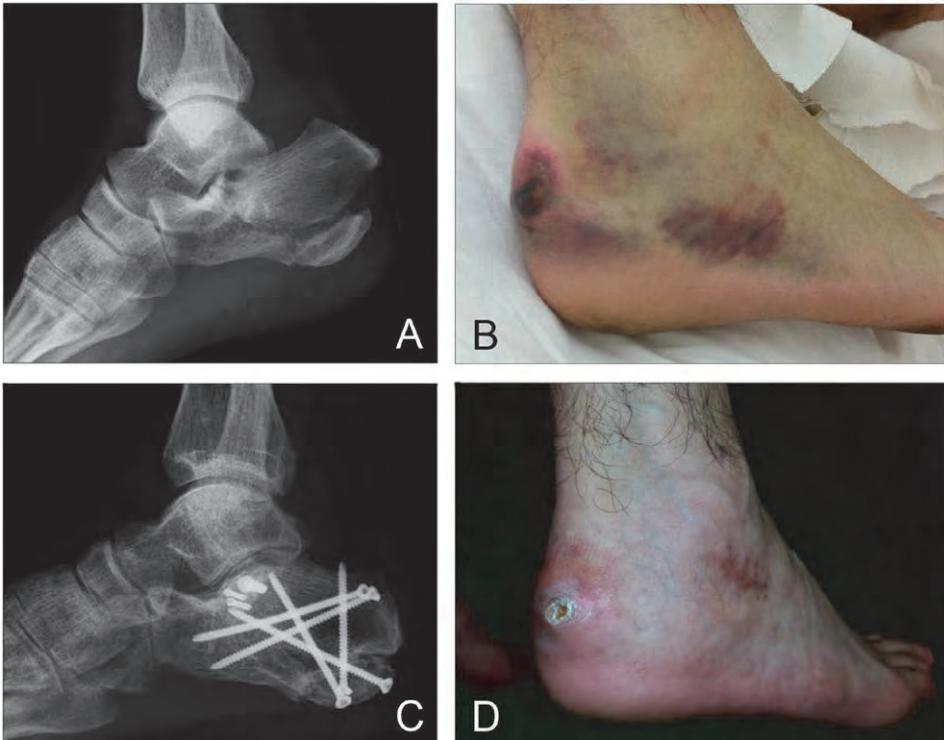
A. Lateral radiograph of a tongue-type DIACF at first hospital presentation, with severe displacement of the posterior tuberosity of the calcaneus. B. Presence and impending posterior soft tissue compromise (e.g., hematoma, blisters, and necrosis) due to the specific fracture displacement resulting in high tension on the skin. C. Status after Open Reduction and Internal Fixation (ORIF), 5 months after trauma. D. Wound healing after ORIF via Sinus Tarsi Approach.
